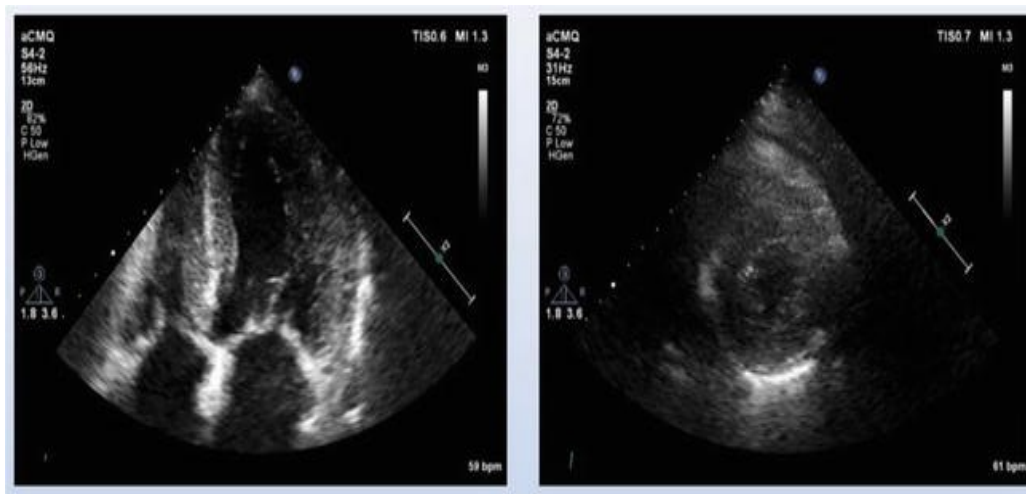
2D echocardiogram (apical 4 chamber view and parasternal short axis view) in a patient with AL type cardiac amyloidosis revealing increased thickness of the left ventricular walls.
